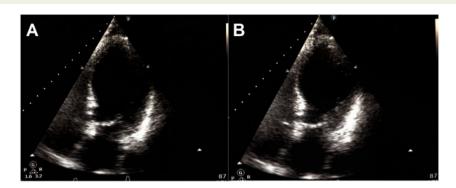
Trans-thoracic echocardiography images. Apical four-chamber views showing (A) end-diastolic and (B) end-systolic frames demonstrating LV apical ballooning.
